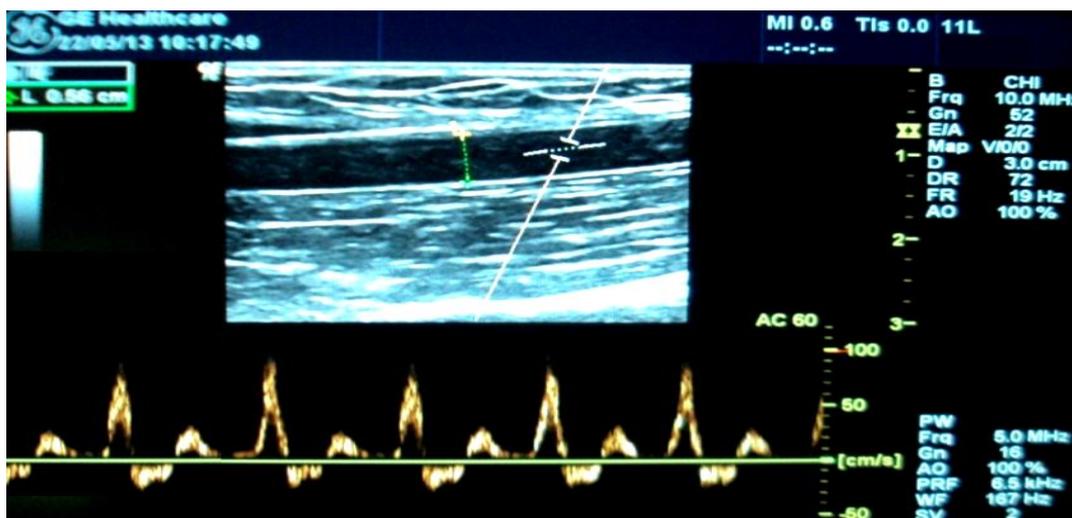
The ultrasound assessment of the diameter of the brachial artery
